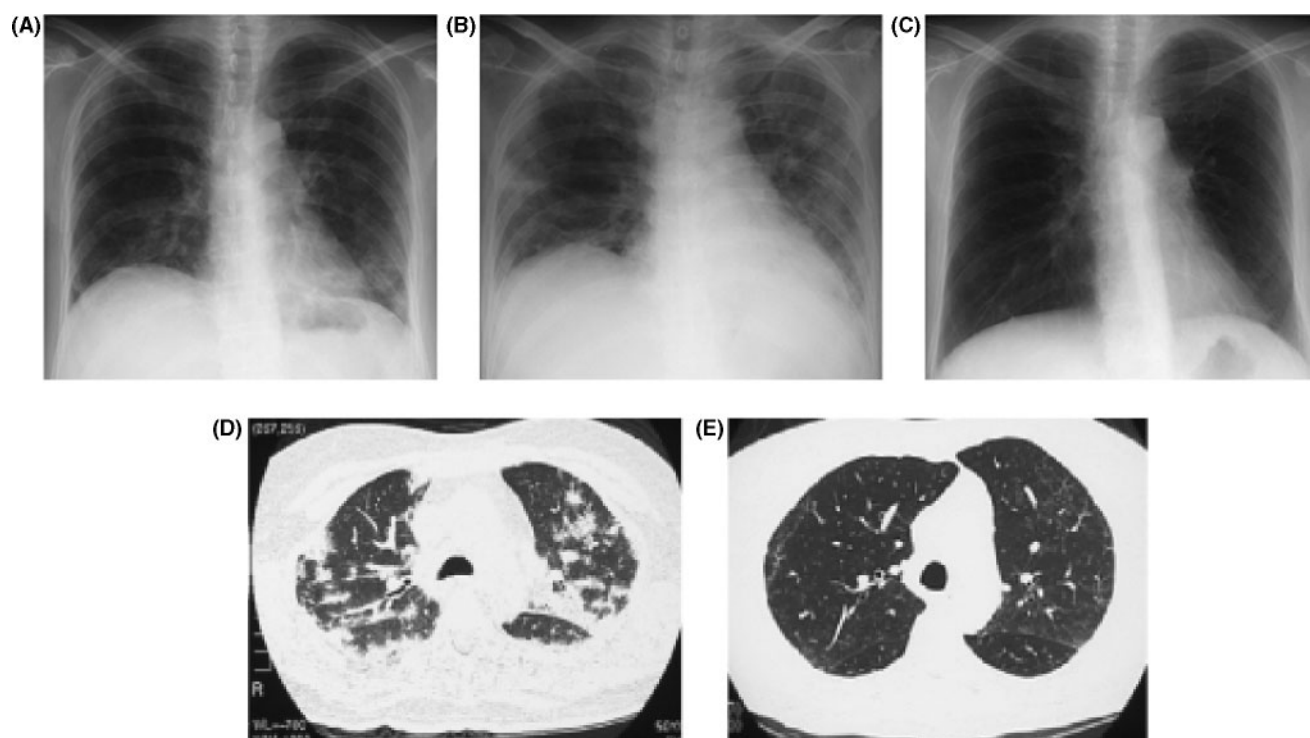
Chest X-ray and HRCT in a case of a 50-yr-old woman (case 11). Chest X-ray films before MPSL pulse therapy (A) and 2 weeks after MPSL therapy (B) showing progressive interstitial pneumonia. HRCT before cyclophosphamide is shown in (D). Dramatic improvement was seen 11 months after IVCYC by chest X-ray (C) and HRCT (E).
